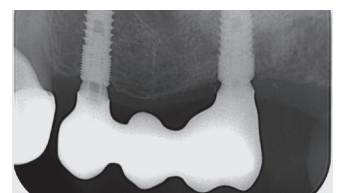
Periapical radiograph view of 2 years followed up.
